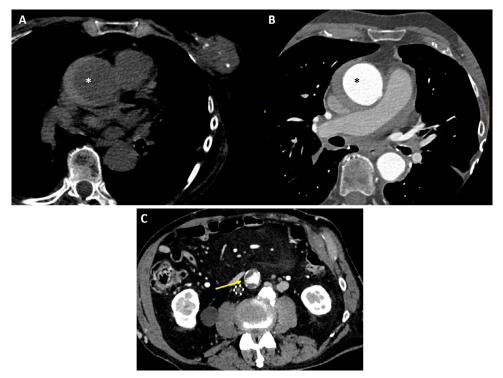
Computed tomography of intramural hematoma and penetrating aortic ulcer. Computed tomography in an axial view in a patient with an intramural hematoma (* showing the bleeding region) before (A) and after (B) the administration of iodine contrast. Of note, the hyperintensity of the aortic wall in the precontrast image. (C) Computed tomography in axial view showing ulcerated plaque in the descending aorta.
